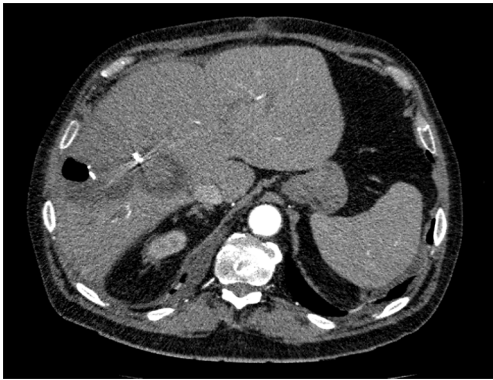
Postprocedural contrast-enhanced computed tomography.
